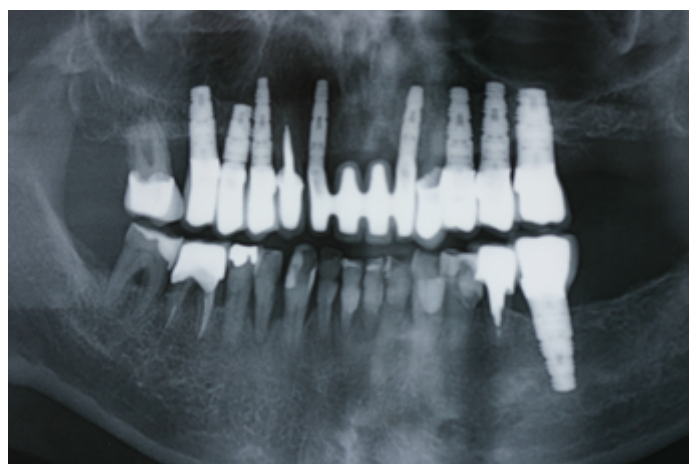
Case A: Panoramic radiography of a patient at a recall appointment. The implants appear longer and wider.
